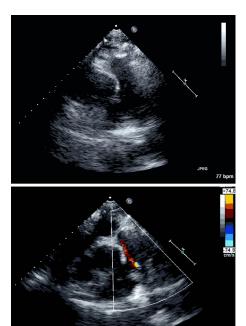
Video showing the patent ductus arteriosus flow on colour Doppler jet reflecting blood flowing back into the pulmonary artery owing to the overlying connection from the aortic arch
